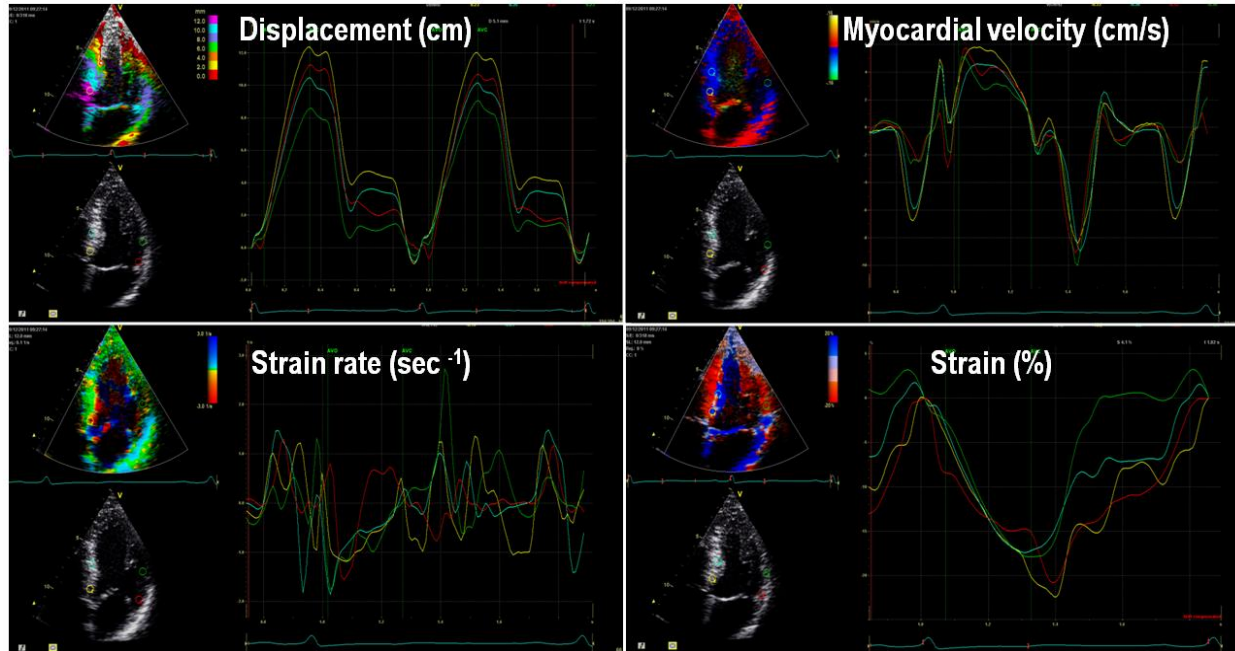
Tissue Doppler imaging. Color-coded tissue Doppler imaging provides local myocardial displacement information from which parameters of myocardial function such as velocity, strain and strain rate can be derived.
